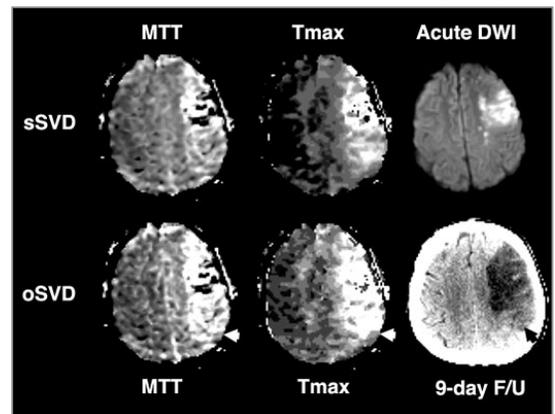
sSVD and oSVD MTT and Tmax maps along with acute DWI and 9 day F/u exam for 57 y.o male imaged <7h from stroke onset and NIH SSS=15. Lesions on F/u correspond best with those on oSVD MTT and Tmax maps.
